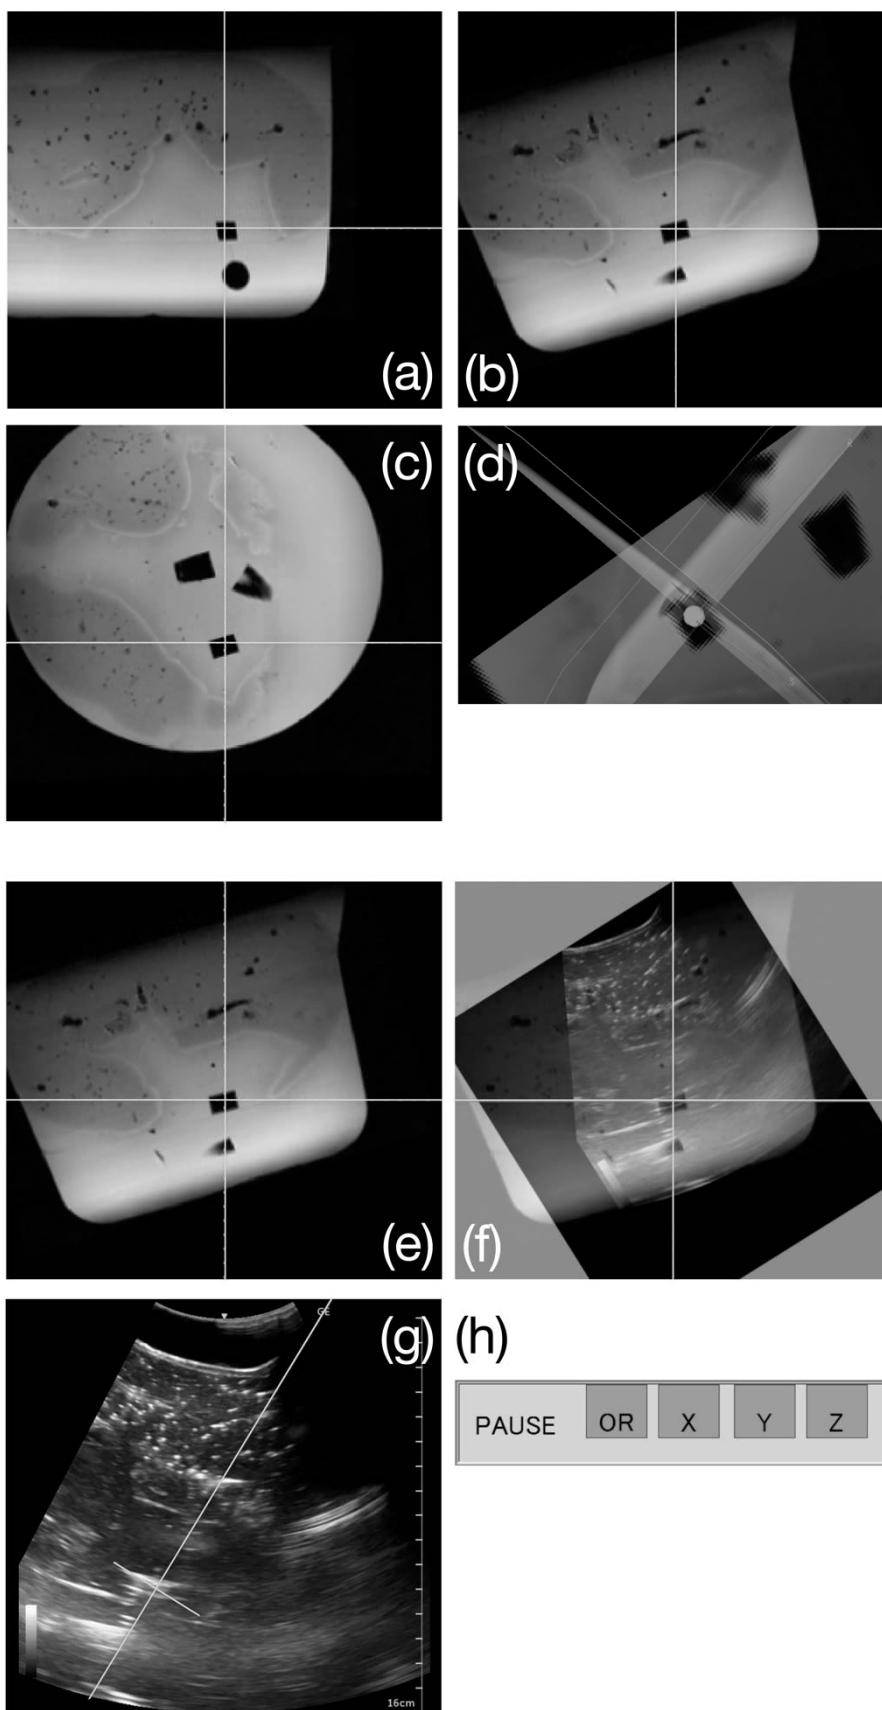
Typical guiding images displayed on the (a)–(d) upper and (e)–(h) lower in-room monitors: (a) in-plane-0 multiplanar reconstruction (MPR) parallel to the needle path), where the vertical line represents the planned needle path, and its intersection with the solid horizontal line represents the target location; (b) in-plane-90 MPR; (c) MPR perpendicular to the needle path; (d) virtual bird's eye view; (e) corresponding MPR (in-plane-90 image in this figure; (f) ultrasound (US) image plane fused with the in-plane-90 image; (g) US image plane, where the long solid line represents the planned needle path, and the intersection with the short solid line represents the target location; (h) device status, i.e., (left to right) virtual remote center of motion mode status and motion limit alerts for the three axis active linear base stage.
